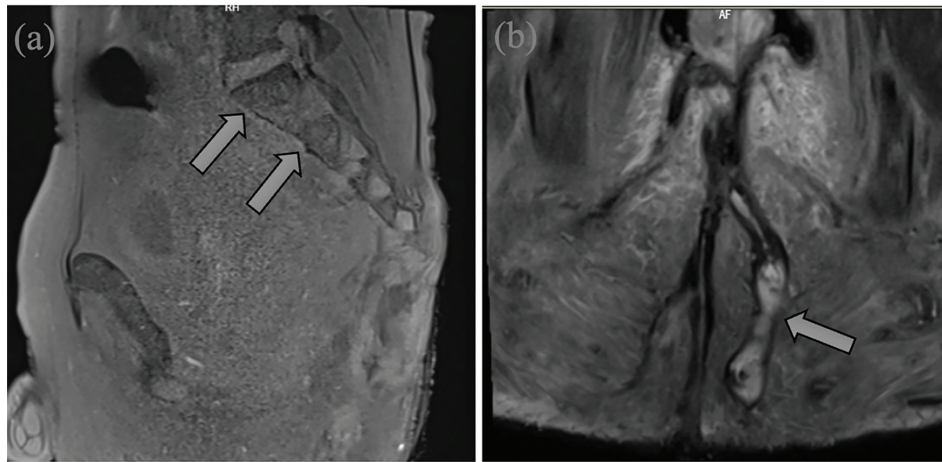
Magnetic resonance imaging (a) concomitant osteomyelitis in the sacral vertebrae (arrow), (b) complicated perianal fistula (arrow) starting from the anal canal and extending superiorly along the presacral area, opening to the skin at the level of the gluteal sulcus, containing abscess formations
